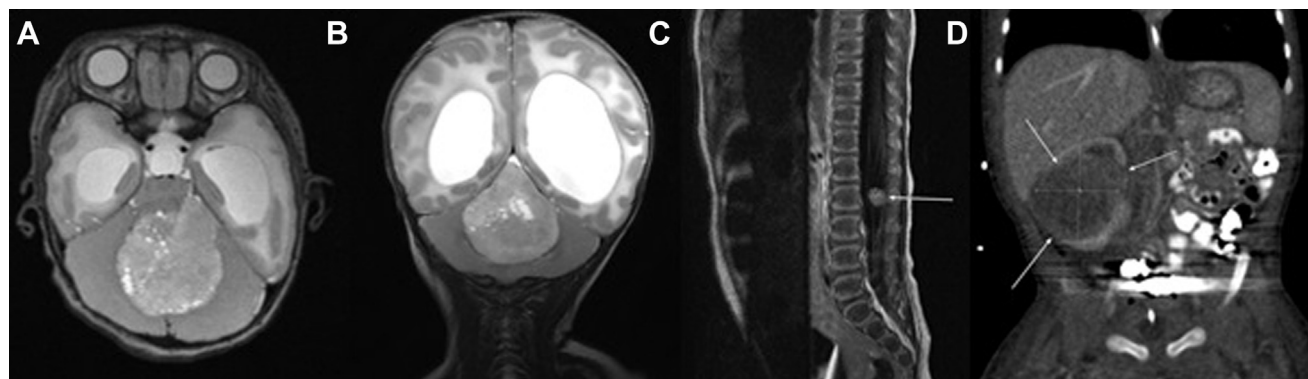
Initial magnetic resonance imaging (MRI) of the head and spine and computed tomography (CT) of the abdomen. (A) Initial brain MRI demonstrates a 4.2-cm posterior fossa mass extending through the left cerebellopontine angle, causing obstructive hydrocephalus on axial T2 imaging. (B) Coronal T2 MRI of the brain. (C) MRI of the lower spine reveals
